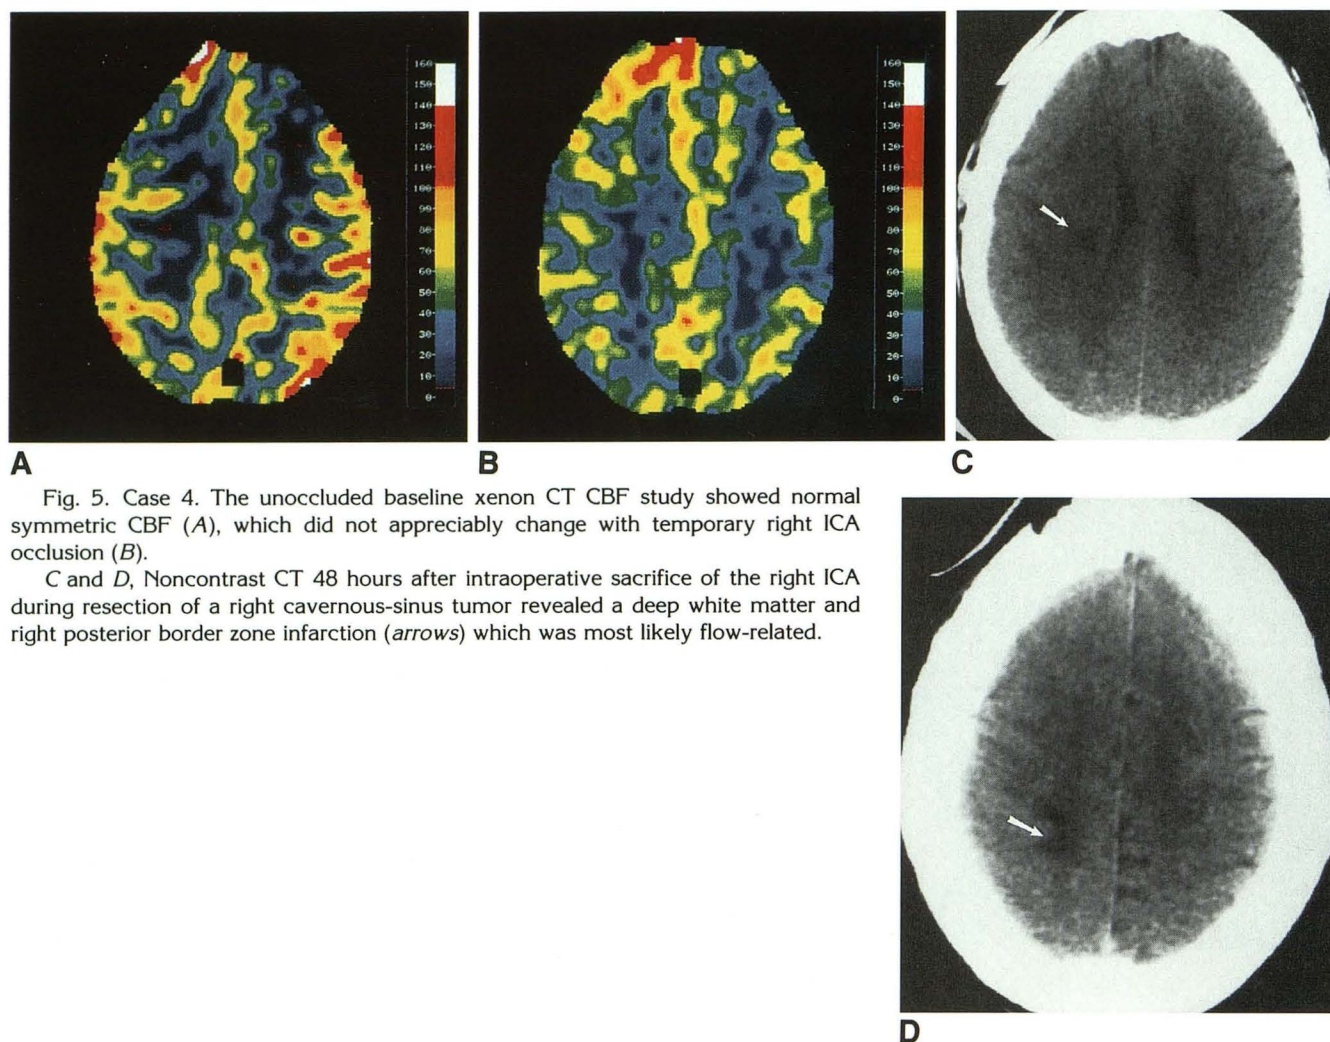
Case 4. The unoccluded baseline xenon CT CBF study showed normal symmetric CBF (A), which did not appreciably change with temporary right ICA occlusion (B).
